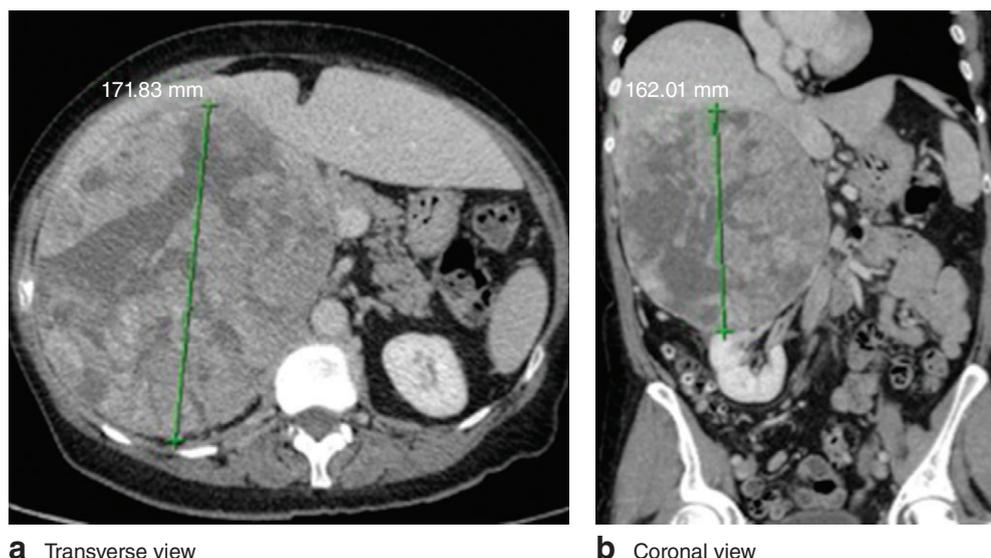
Appearance of adrenocortical carcinomas on cross-sectional imaging. a Transverse and b coronal views on CT of a large right adrenocortical tumour in a woman with virilization syndrome
